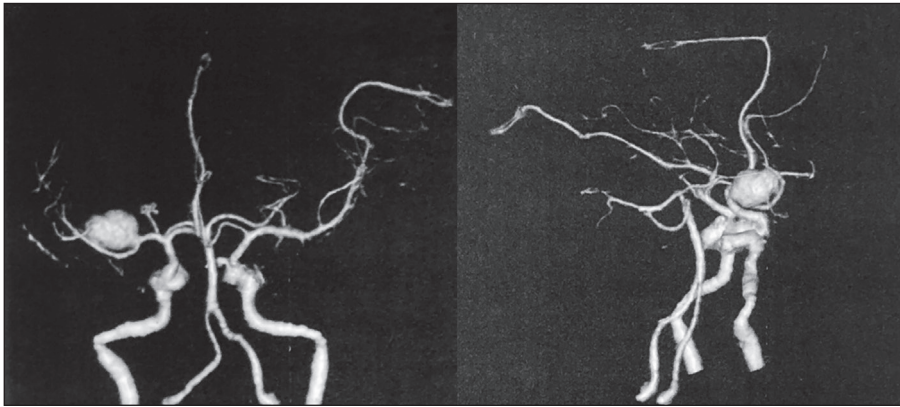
The computed tomography angiography examination on admission. It shows a right MCA aneurysm.
